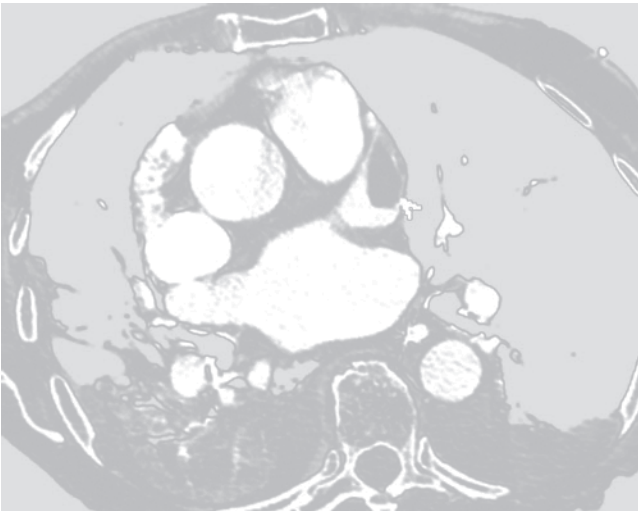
Forty-seven-year-old female with atypical chest pain. Orthogonal MPR views of the left atrium from a CCTA (a, b) demonstrate left atrial enlargement with heterogeneous enhancement of the left atrial appendage. No thrombus was identified on echocardiography. Heterogeneous
